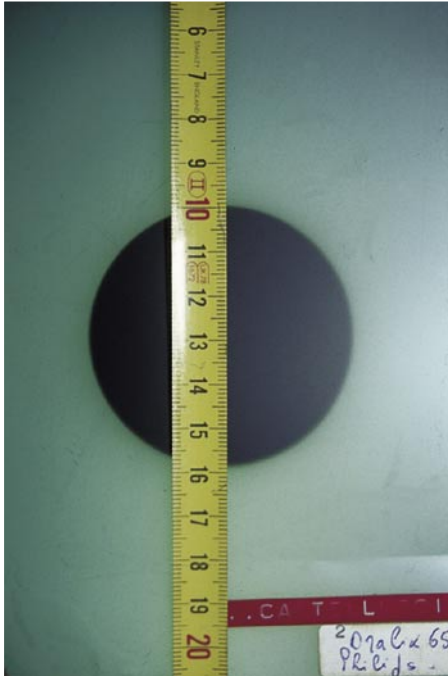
The diameter of the well collimated X-ray beam must not exceed 6-7 cm.
